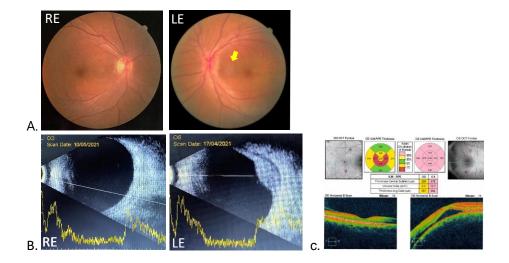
The Clinical condition at 4-month follow-up. A. Fundus photography showed normal right eye and optic nerve head edema with hyperpigmentation which extends to the macula on the left eye (arrow). B. B-Scan Ultrasound showed hyperechoic subretinal mass on the left eye with unclear T-sign. C. Macula OCT showed subretinal fluid on the left eye.
